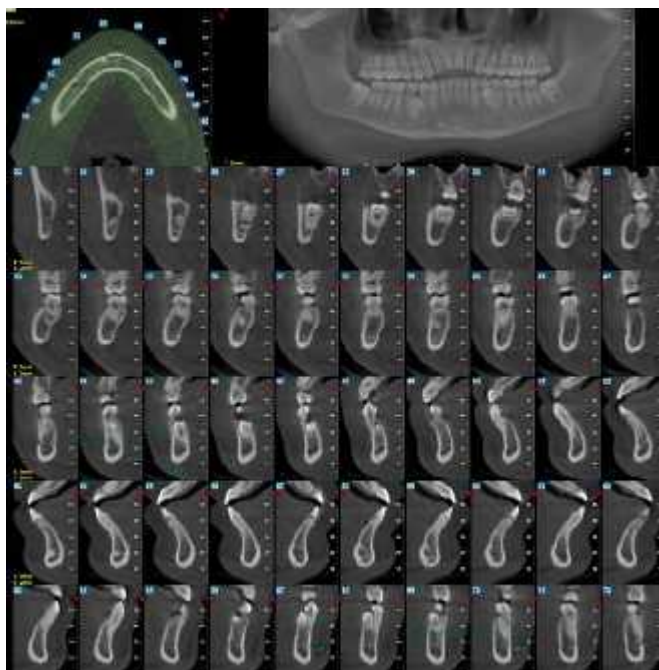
CBCT of mandible showing exact location of bilateral supernumeraries and their relation with adjacent vital structures
